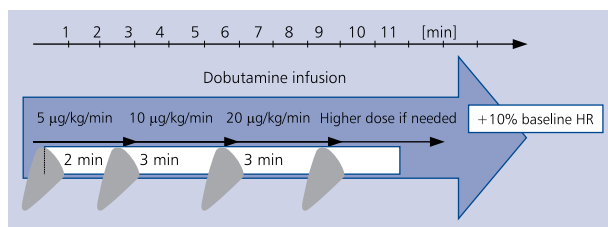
Protocol of dobutamine infusion during low-dose dobutamine stress testing. Increasing doses of dobutamine infused every 3 min with the intention to augment heart rate (HR) at approximately 10% of its baseline value. Grey beams represent timing of echocardiography images acquisition: 2 min after an increase in dobutamine dose
